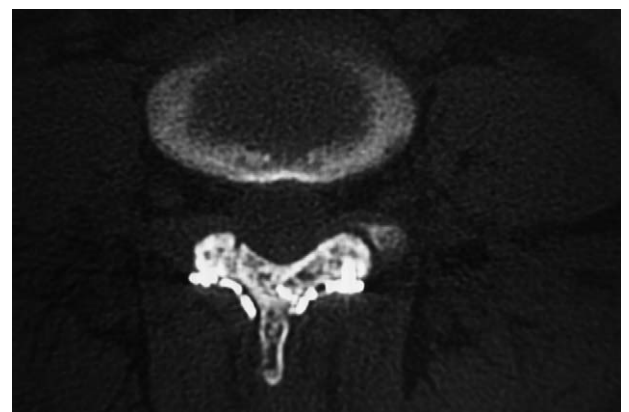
Six-month postoperative CT scan. Six-month postoperative CT scan shows bony fusion. CT=computed tomography.
